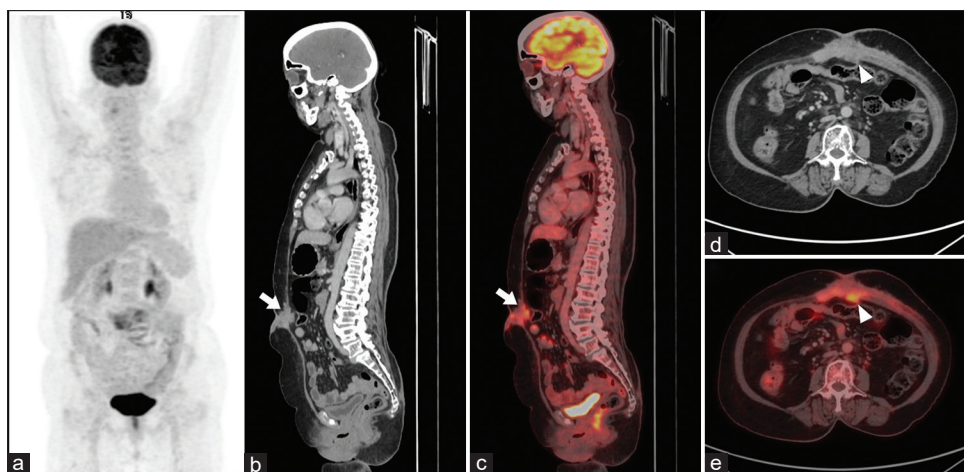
18-F FDG PET-CECT images of a 67-year-old female performed 5 years after laparoscopic cholecystectomy for cholelithiasis. (a) Maximum intensity projection image showing focal hypermetabolism in the umbilical region and no other site of pathological tracer uptake in the whole body. (b and c) The sagittal section of CECT and fused 18-F FDG PET-CECT images, respectively, demonstrate heterogeneously enhancing hypermetabolic soft-tissue thickening involving the skin and subcutaneous tissues and extending posteriorly to involving rectus abdominus muscles (white arrows) with associated perilesional fat stranding. (d and e) Trans axial CECT and fused 18-F FDG PET-CT images, respectively, show the lesion in the axial section (white arrowheads). 18-F FDG PET-CECT: Flourine-18 fluorodeoxyglucose positron emission tomography-contrast enhanced computed tomography, CT: Computed tomography
